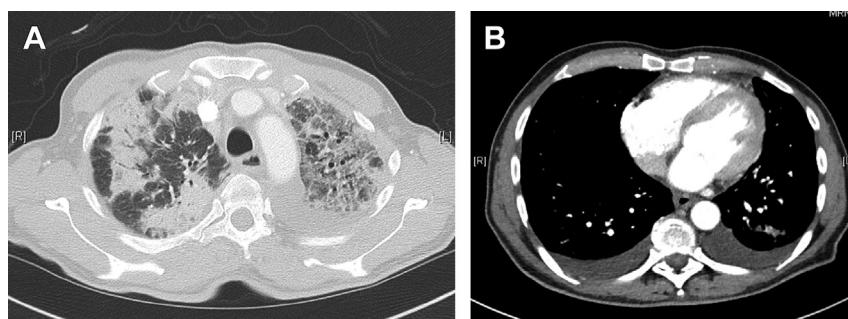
Chest CT of a patient with EGPA. (A) Lung window demonstrating alveolar opacities and ground-glass attenuation; (B) mediastinal window showing bilateral pleural effusion due to eosinophilic myocarditis with heart failure.
